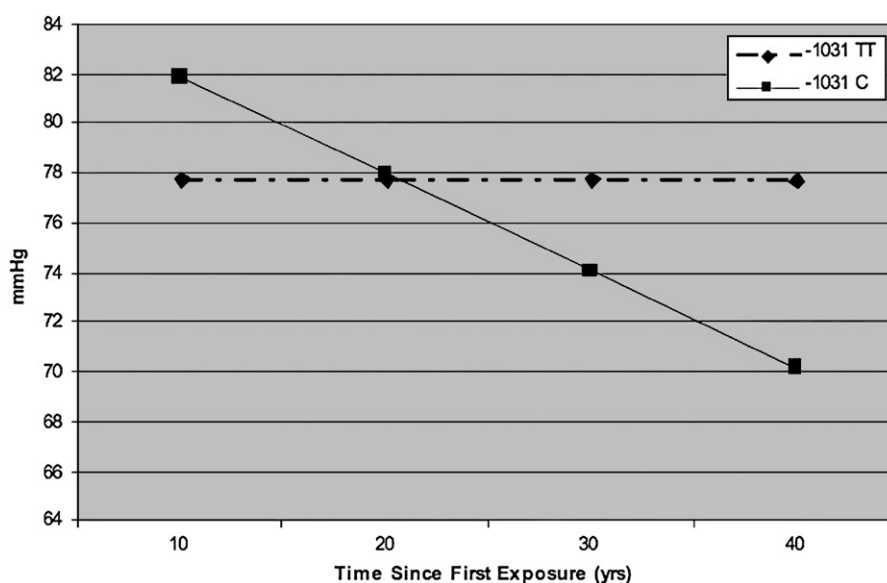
Change in Pao_{2m} values (in millimeters of mercury per year) by -1031 genotype CC/CT (solid line) versus TT (dashed line) over time modeled between 10 and 40 years since first beryllium exposure ($P = .03$) adjusted by sex, height, smoking history (current, former, never), and age at test.
